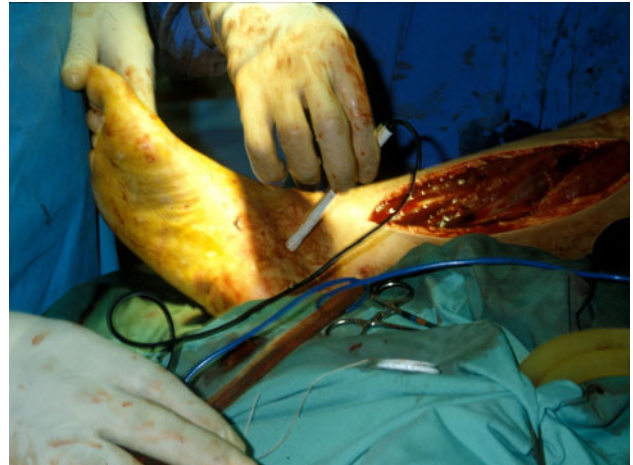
Figure depicts the use of the Doppler probe to detect triphasic flow signals in the posterior tibialis pulse after the interposition graft was redone. Notice four-compartment fasciotomies of the foreleg
